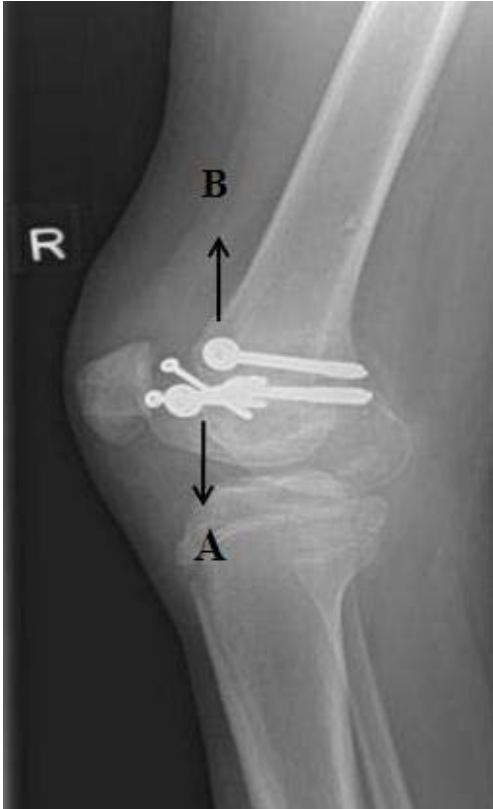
Radiograph of Right Knee Shows Cannulated screw fixation for femoral condylar fracture. A-Condylar fracture, B- Cannulated screws
